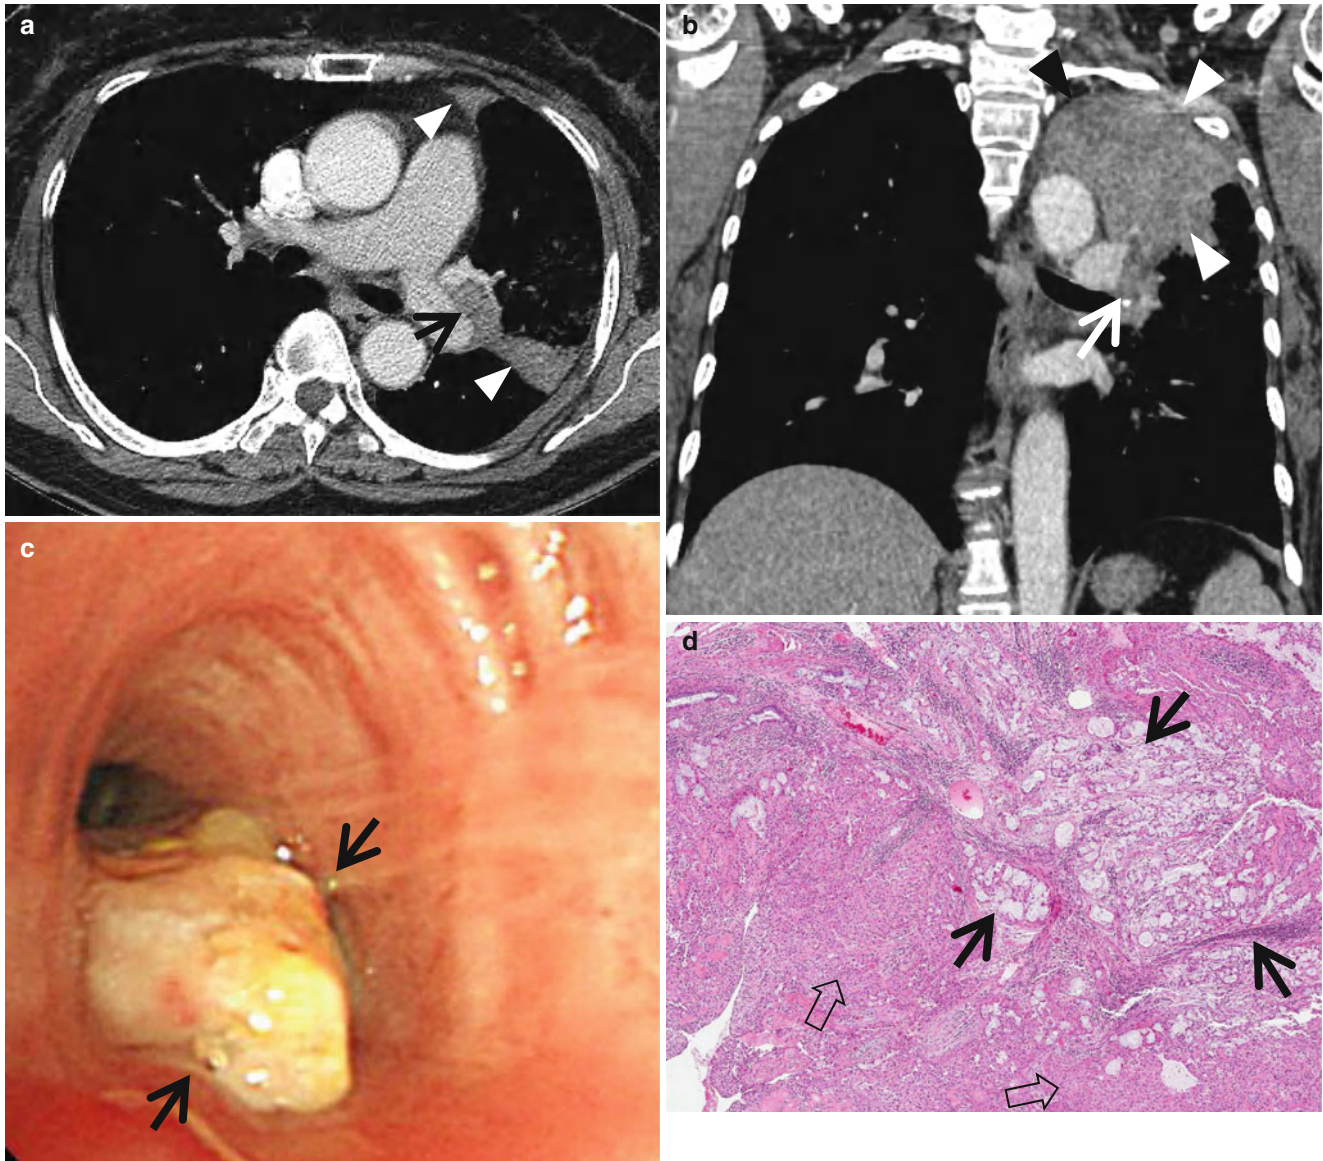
Left upper lobar atelectasis owing to mucoepidermoid carcinoma arising from the left upper lobar bronchus in a 69-year-old woman. (a) Enhanced CT scan (2.5-mm section thickness) obtained at level of the distal left main bronchus shows an endobronchial nodule (*arrow*) obstructing the left upper lobar bronchus. Also note the atelectatic left upper lobe (*arrowheads*). (b) Coronal reformatted (2.0-mm section thickness) CT scan demonstrates endobronchial nodule (*arrow*)
